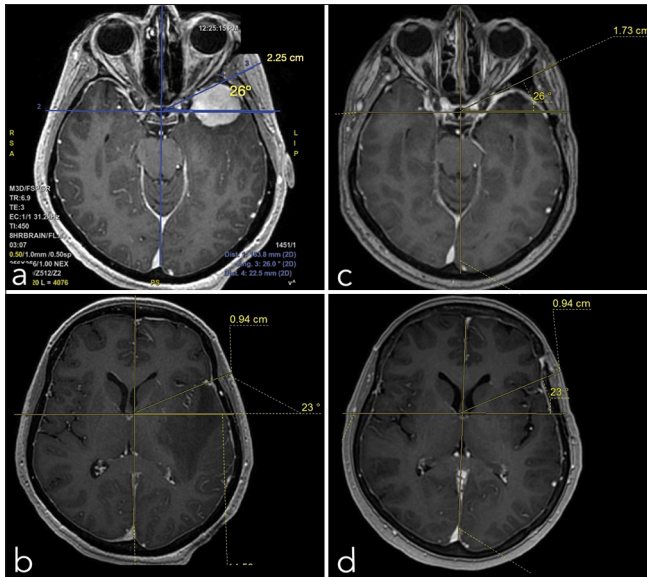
Pre (a;b) and postoperative (c;d) temporal thickness magnetic resonance imaging measurements (example case # 11). This distance was defined as the widest distance between the skull's outer cortical bone and skin surfaces at the level of the anterior clinoid process (D1) and at the level of the foramen of Monro (D2). To avoid errors between pre and postoperative measurements, we used the same angle drawn from the intersection of the midline and a horizontal line (in the x plane) crossing the sella turcica in D1. In D2, the center of the angle was the intersection of the midline and a horizontal line (in the x plane) crossing the foramina of Monro.
